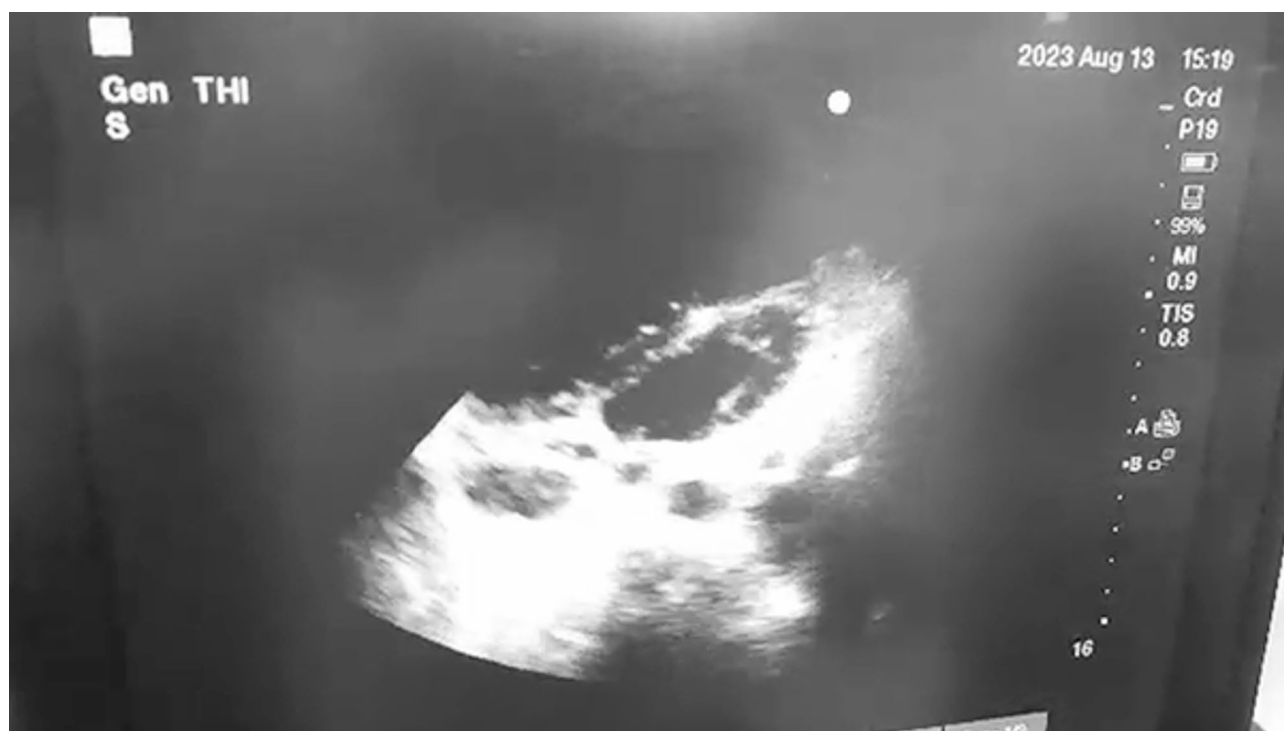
Transthoracic echocardiography imaging. Short axis view at Mid ventricle level. D-shaped Left ventricle in and flattening of the interventricular septum suggests RV volume overload during diastole
